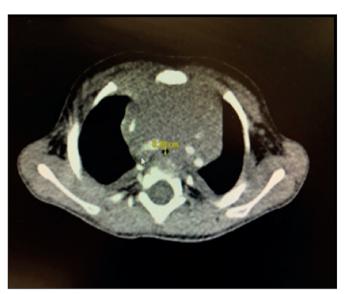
Computed Tomography of the patient, CT scan shows the narrowest part of the trachea
